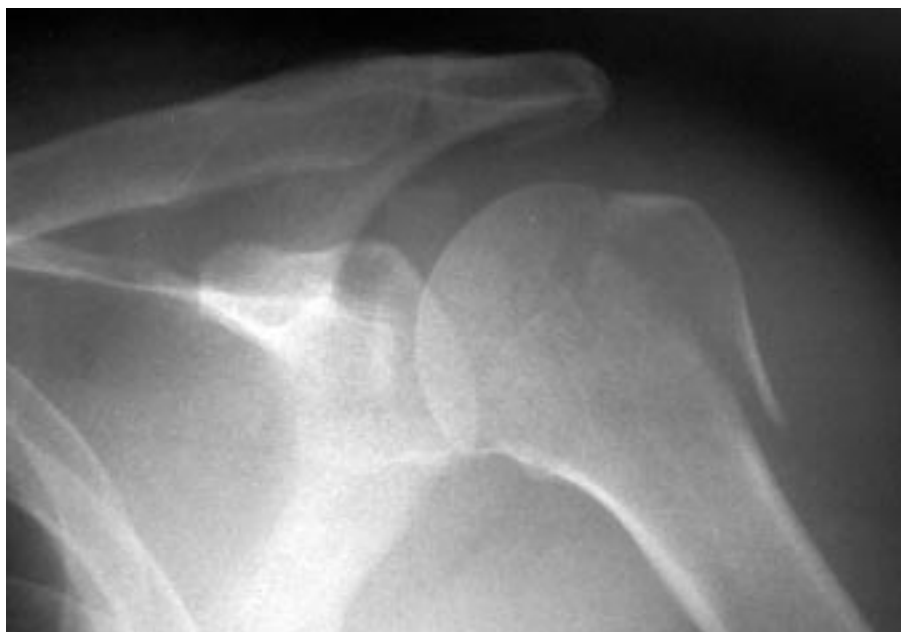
X-ray confirmed the close reduction of the dislocated shoulder.
